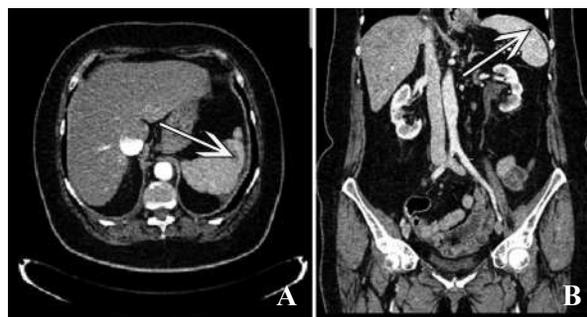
Abdominal contrast enhanced computed tomography image: hypodense lesion, present in the spleen, approximately 40 x 12 mm in size, indicating an infarction. A) transverse plane; B) coronal plane
